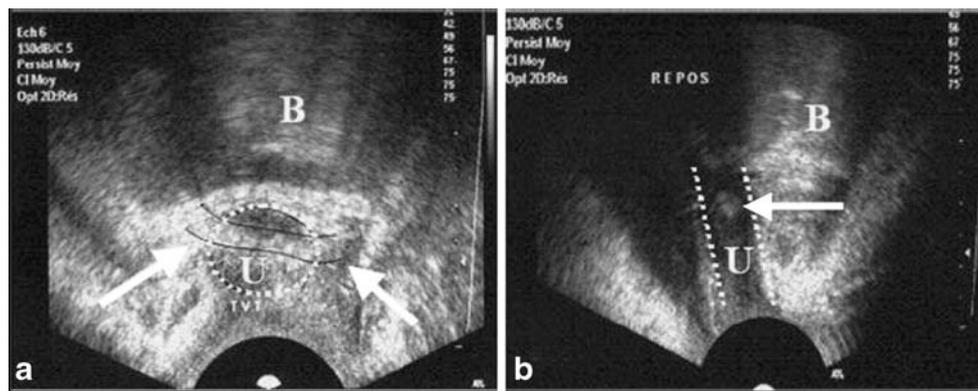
Intra-urethral ultrasound appearance of an intraurethral placed polypropylene sling: a in the transverse angulated plane, the sling, *underlined by black lines* and identified by *arrows*, is seen crossing the lateral urethral walls. The circumference of urethra is indicated by
